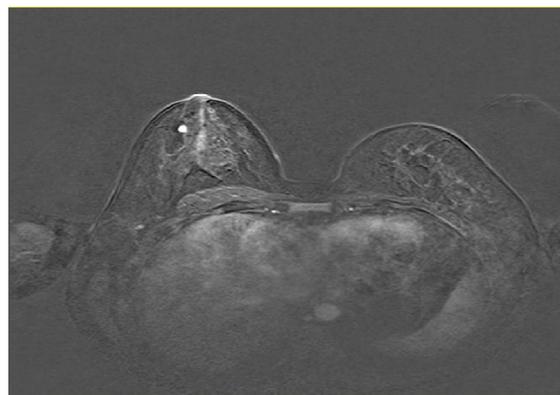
MRI of Ductal carcinoma; Speculated right enhancing mass in 37 years old women has seen.
